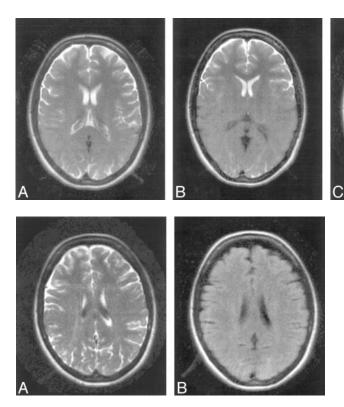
Healthy volunteer. Transverse standard single-shot, fast spin-echo, fluid-attenuated inversion recovery (SS-FSE-FLAIR) (A) and image obtained with a non–section-selective inversion pulse (B). Both were acquired with moderate nodding. There is much better control of motion artifact in B.
